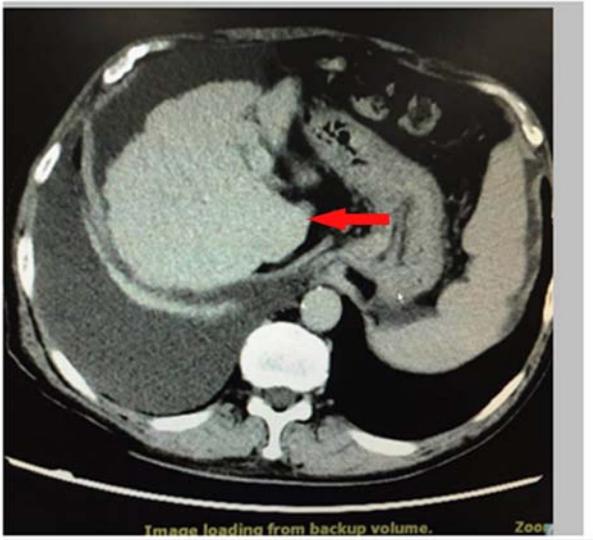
Abdominal CT prior to liver transplantation. After hospitalization, an abdominal CT indicated bilateral pleural effusion, cirrhosis and ascites, as shown by the red arrow.
